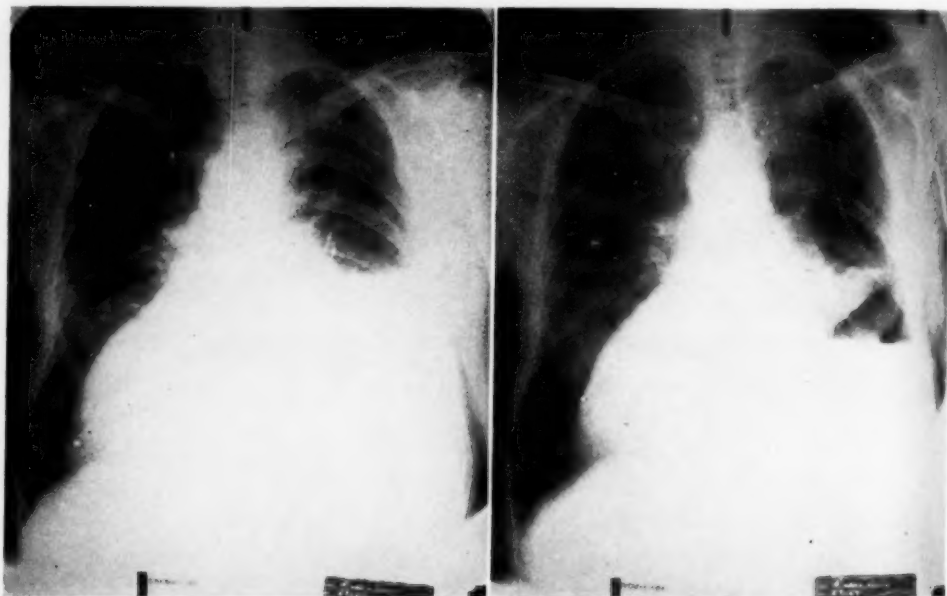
Case CS 24, radiographs before (left) and after (right) thoracentesis in a case of right hydrothorax with chronic myocardial failure.
